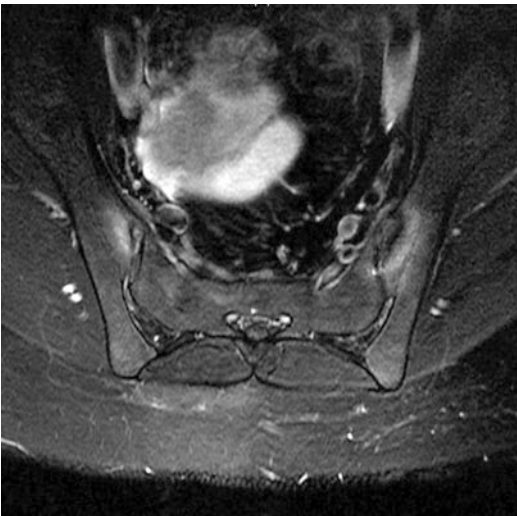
MRI of the sacroiliac joints shows reduced bilateral sacroiliac joint space with symmetrical focal bone marrow edema along the iliac side of both joints
